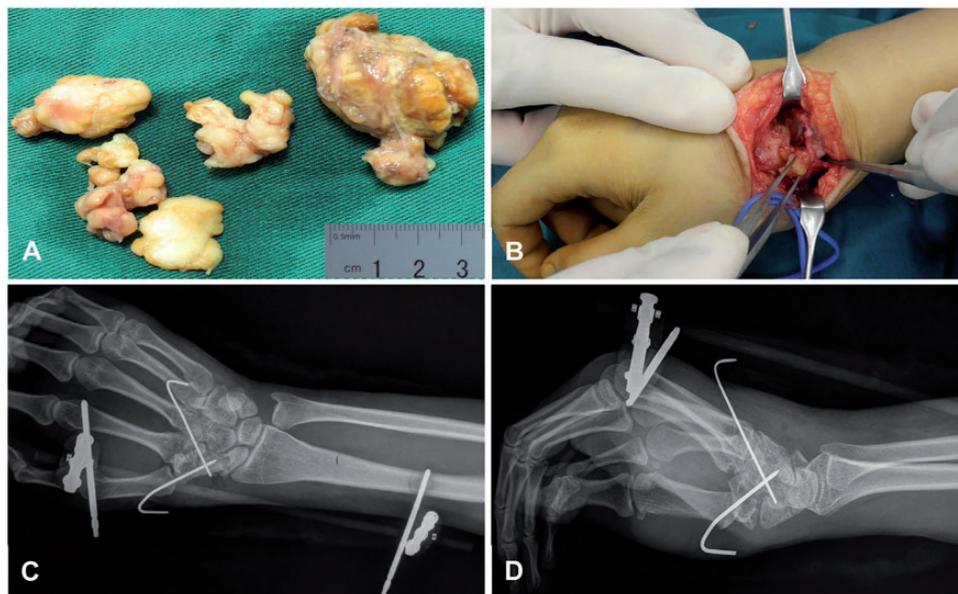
Yellowish-tan to mottled brown-coloured masses with typical multi-lobulated appearance are excised from the lesion (A). Intraoperative view showing obvious adhesion to surrounding tissue (B). Postoperative radiographs with external fixator supported and iliac crest bone autologous graft (C, D). The colour version of this figure is available at: <http://imr.sagepub.com>.
